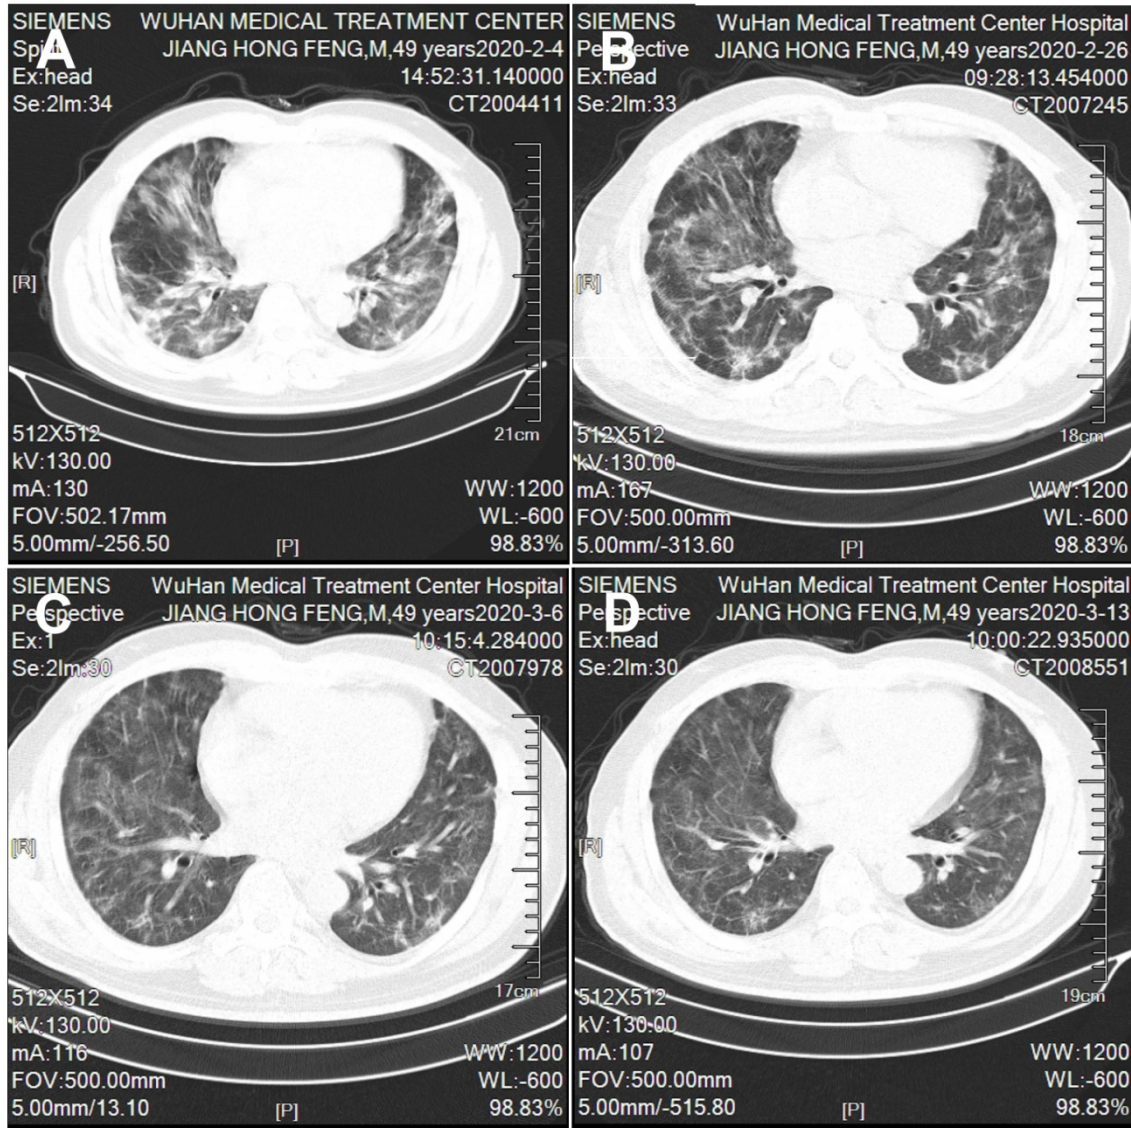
CT lung scanning graph of patient on different days. A. the graph on February 4, 2020. B. the graph on February 4, 2020. C. the graph on March 6, 2020. D. the graph on March 13, 2020
